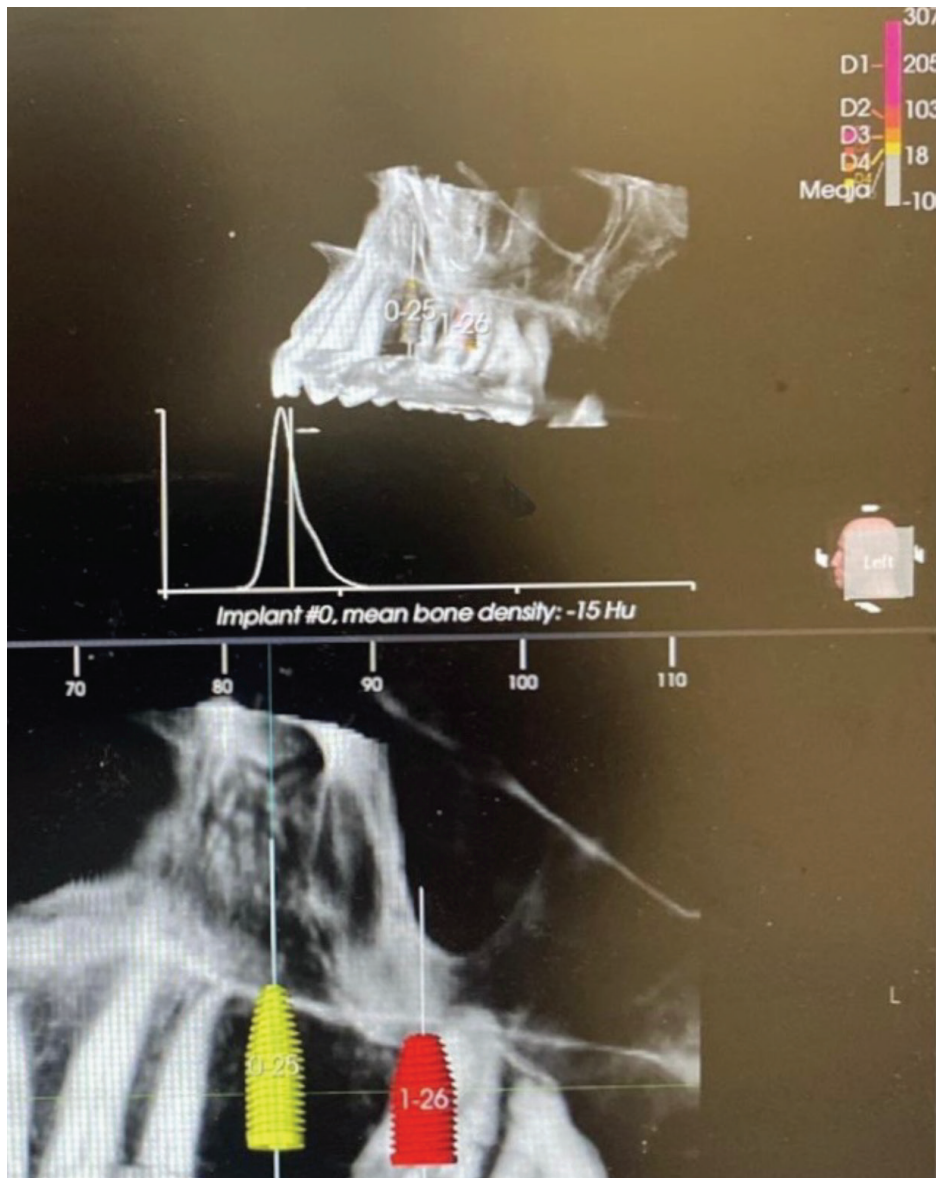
CBCT and implant treatment plan planification.
